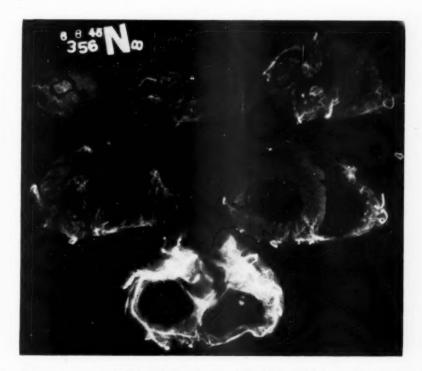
Roentgenogram of the injected heart in Case 146 with lateral infarct outlined in black and the anteroseptal ischemia demarcated by its lack of injection.
